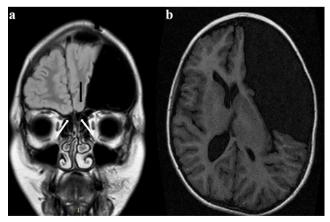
a Preoperative MRI (coronal view) of the exemplary case showing the absence of olfactory bulbs (*white arrows*) and the hypoplasia of the left olfactory sulcus (*black arrow*). The left orbital gyrus and right gyrus are poorly differentiated and partially compressed by the arachnoid cyst; b Note the left, large, sylvian arachnoid cyst (preoperative MRI axial view)
